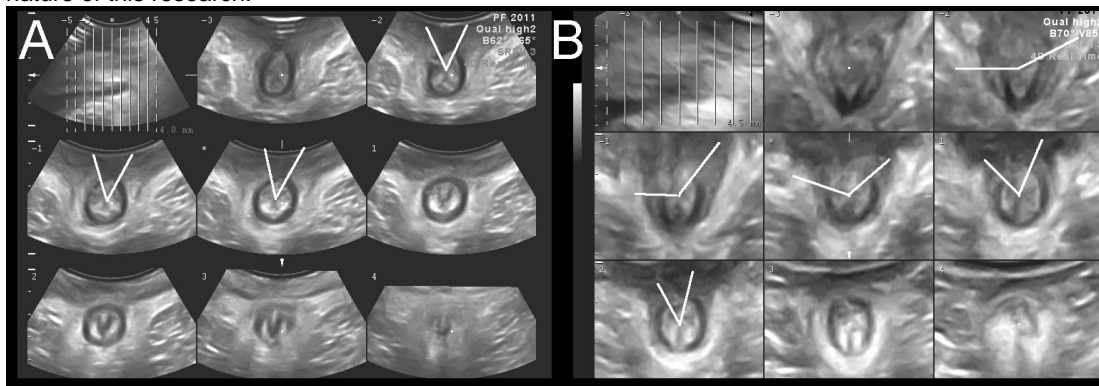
Assessment of EAS and IAS by translabial 4D tomographic ultrasound. (A) shows a partial EAS defect (3/6 slices of EAS length), (B) an IAS defect in 5/6 slices arranged over the entire anal canal. Note that a much higher interslice interval is required for IAS imaging.
